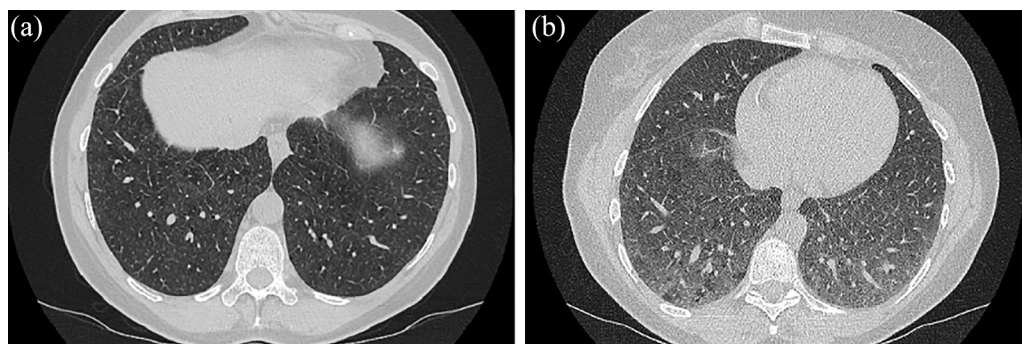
Reticular pattern during inspiration (a) and expiration (b) on high-resolution computed tomography in a patient affected with follicular bronchiolitis in primary Sjögren's syndrome.
